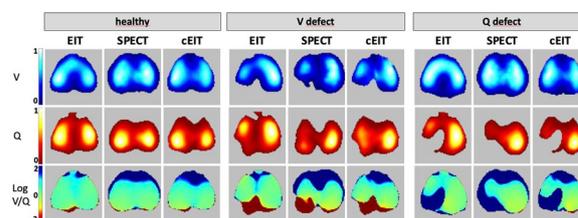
(abstract 000747) Visualization of regional ventilation and perfusion defects using electrical impedance tomography (EIT), single-photon emission computed tomography (SPECT), and calibrated EIT (cEIT). Top row: relative regional ventilation (V); middle row: relative regional perfusion (Q); bottom row: weighted regional V/Q ratio, logarithmic color scale: Zero corresponds to a V/Q of 1:1, 2 corresponds to V/Q = 100:1 (dead space), -2 corresponds to V/Q = 1:100 (shunt)
